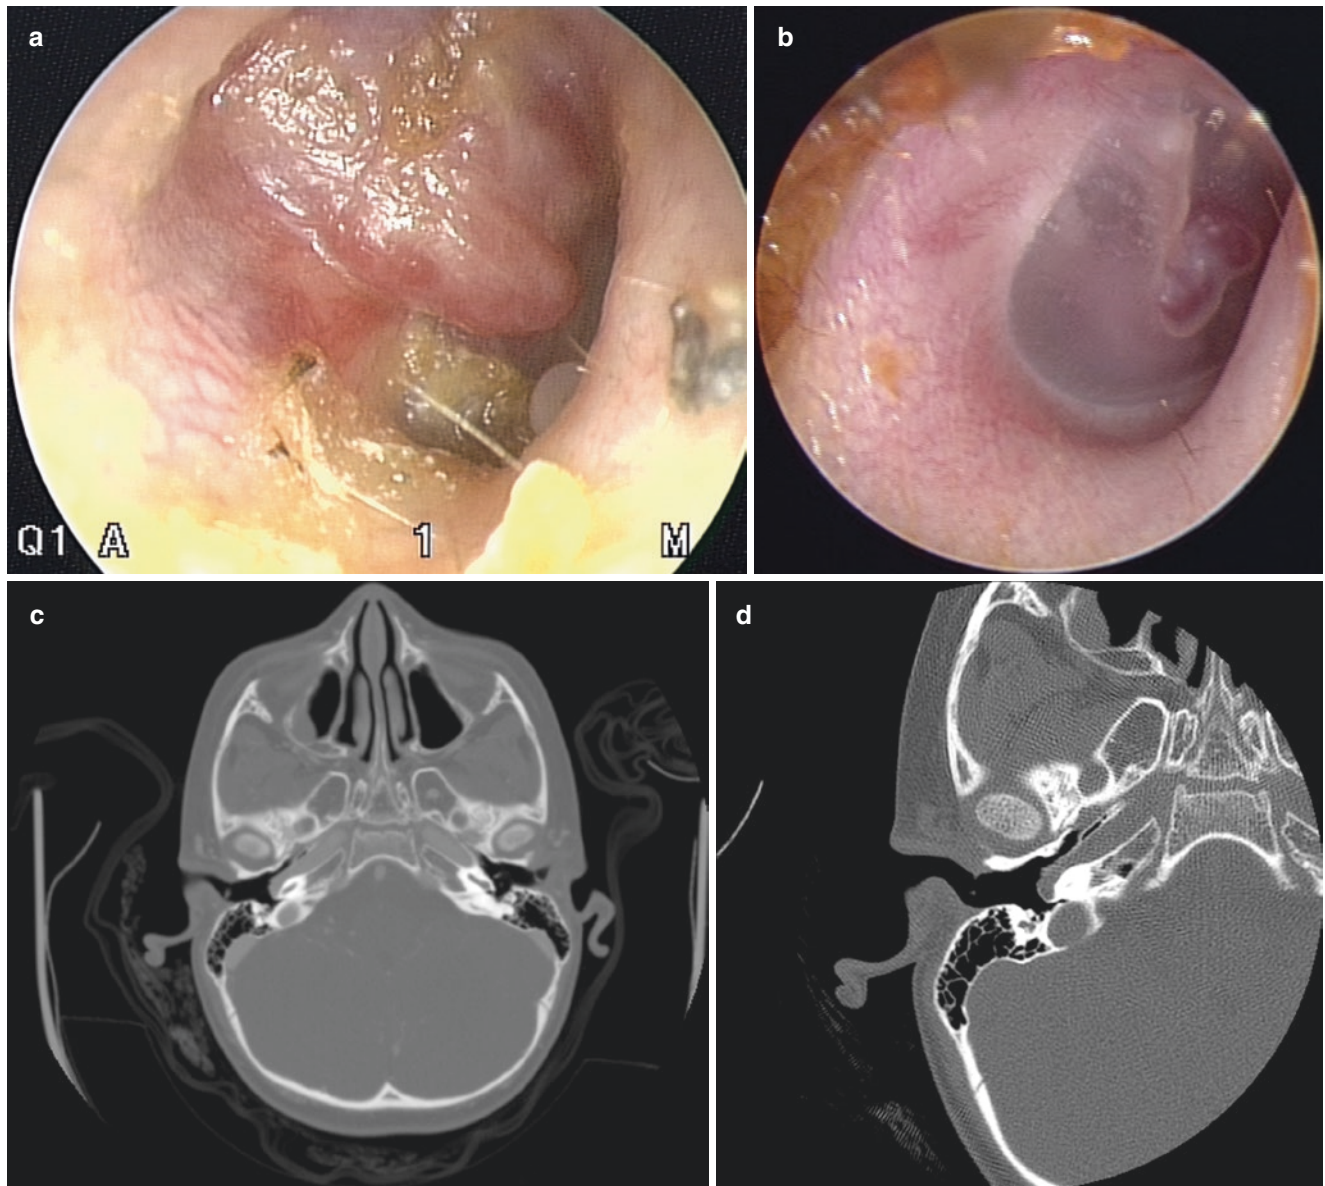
(a) A dull reddish mass behind the eardrum on otoscopy from a haemangioma. (b) Reddish mass behind the right tympanic membrane is an aberrant internal carotid artery. (c) Axial CT of the head and temporal bones showing an aberrant course of the right internal carotid artery. The left carotid canal is normal and covered by bone. The normal bony cover of the carotid artery is absent on the right. This was detected on otoscopic exam as a reddish mass behind an intact otherwise normal
